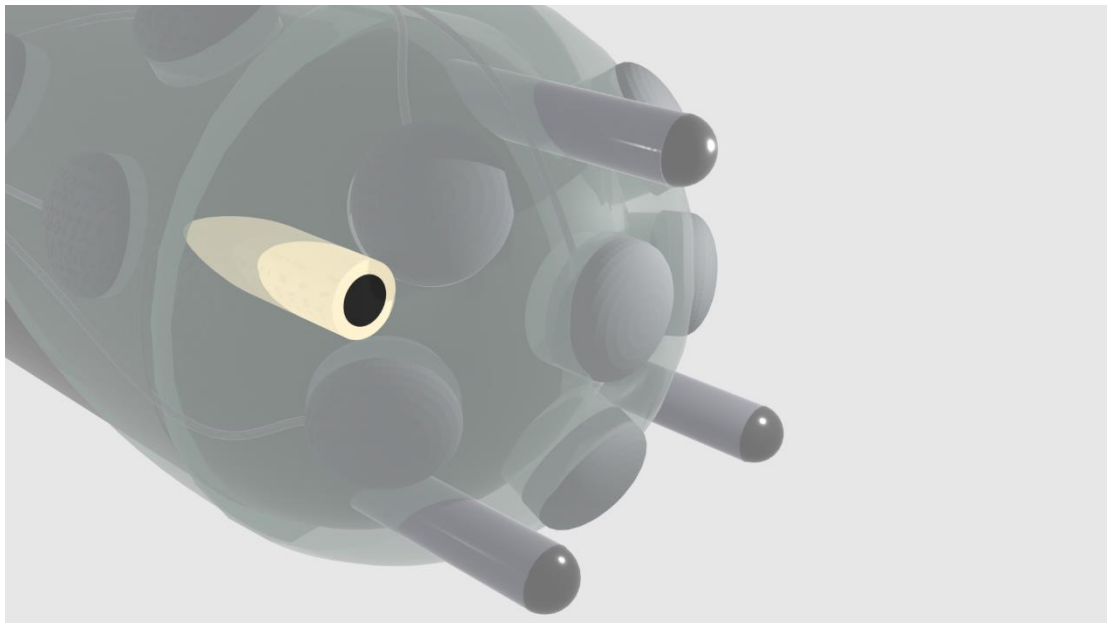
Ultrasound probe
